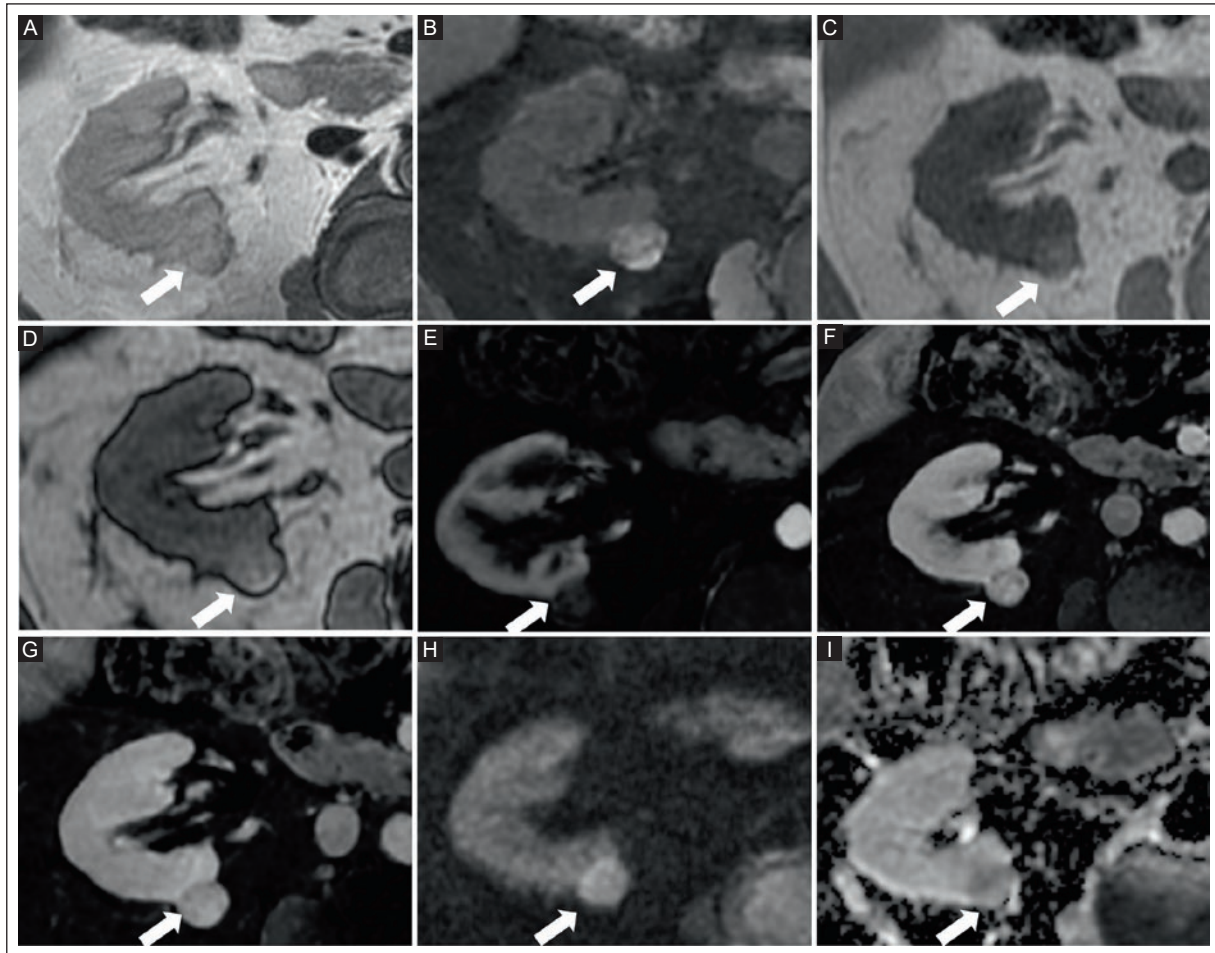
MRI of a 62-year-old man diagnosed with right-kidney papRCC^a. A: well-circumscribed lesion, appearing isointense on T2-WI (arrow). B: the lesion appears mildly hyperintense on T1 fat-saturated non-contrast sequence suggesting hemorrhagic content (arrow). C: in-phase, and D: opposed-phase T1-WI show no signal drop (arrows). E: arterial phase subtraction, F: venous phase subtraction, and G: late phase subtraction show mild and progressive enhancement of the lesion (arrows). H: the lesion appears hyperintense on DWI at b-value 800 s/mm², and I: hypointense on ADC map, corresponding to diffusion restriction (arrows).
